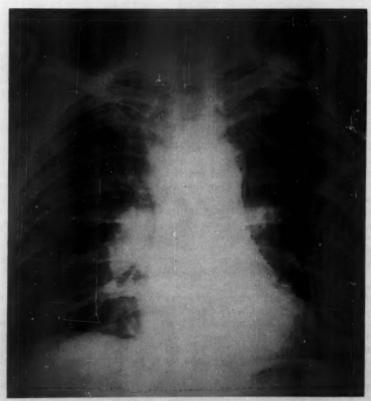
Chest x-ray, demonstrating bilateral hilar adenopathy.
